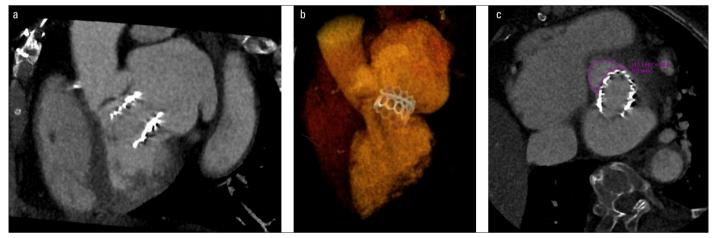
a. CT showing the proper settlement of Myval valve in the mitral ring. b. CT showing the exact position of Myval valve (15% atrial, 85% ventricular). c. CT showing the neo-LVOT area after 26-mm Myval valve deployment to be 303 mm²
